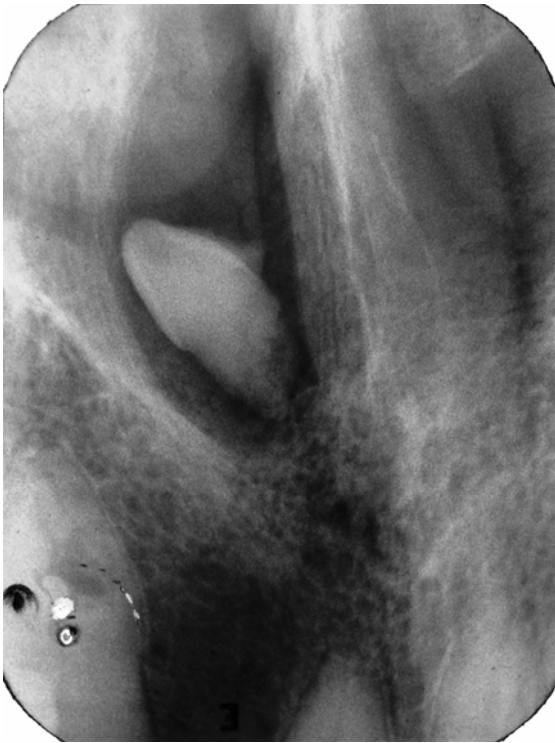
Deeply placed IOPA radiograph showed tooth like radiopacity in right nasal fossa having same attenuation as roots of other teeth visible in radiograph. Radiopaque mass revealed clearly distinguished enamel cap and distinct root.
